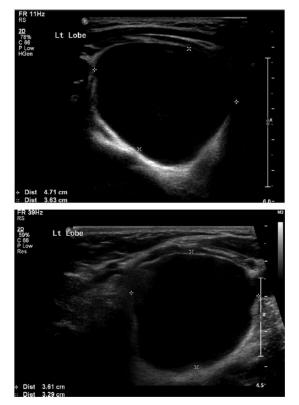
Thyroid ultrasound showing a well-defined cystic lesion measuring 4.7×3.6 cm in maximum diameter; there are internal echoes within the cyst.
